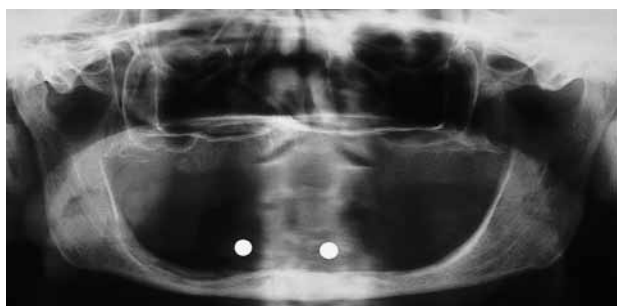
Panoramic radiograph with metallic markers in interforaminal position.
